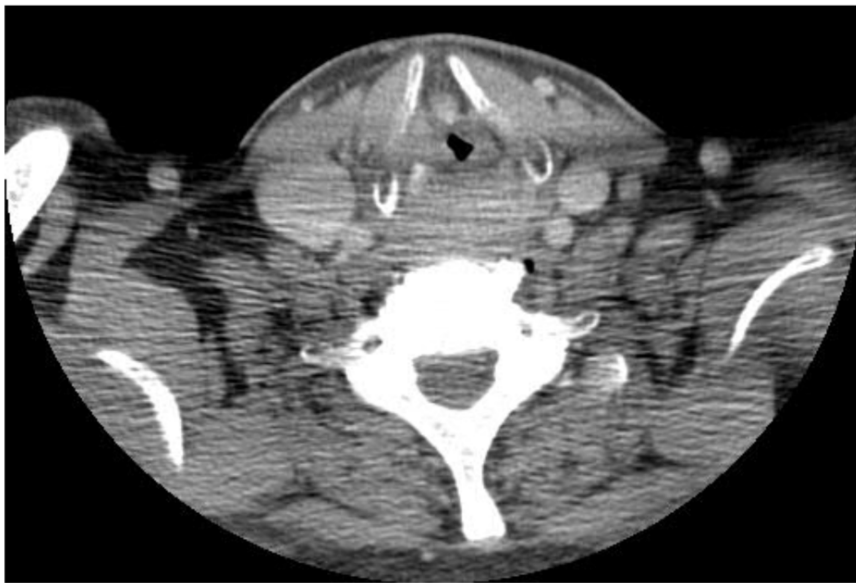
Computed tomography. Initial tumor presented (2006). At this point a wide field laryngectomy, right thyroid lobectomy, and biopsy of the right upper digastric jugular node were performed. Final pathology revealed high-grade mucoepidermoid carcinoma.
